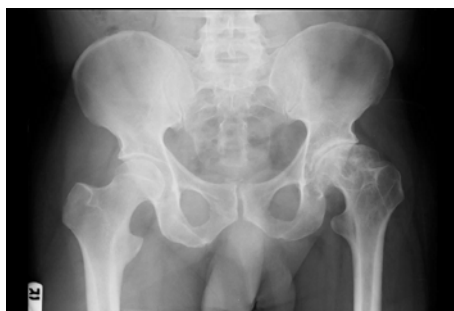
Initial Pelvis with Hip antero-posterior radiograph showing healed Perthes disease with advanced arthritis of left hip joint.
